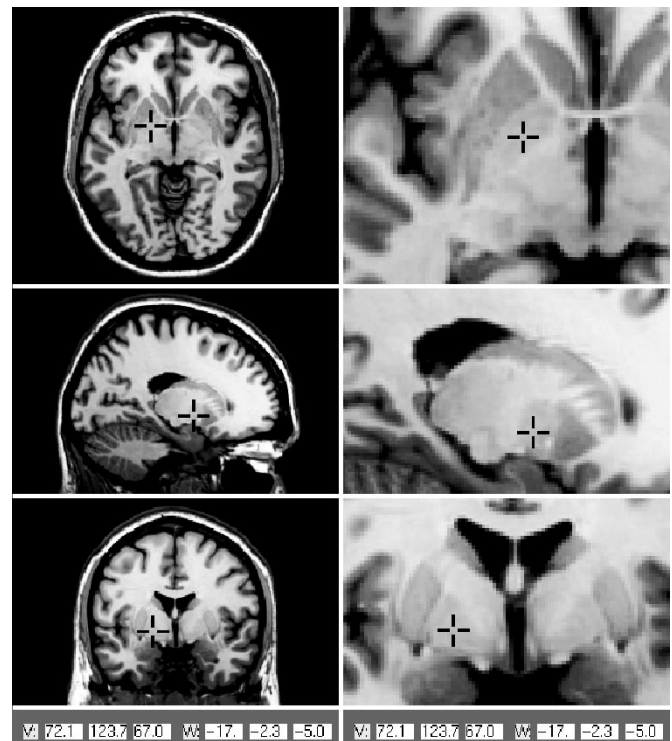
The MRI model data set: axial, sagittal, and coronal cuts (top to bottom), with corresponding detail views (right series).
